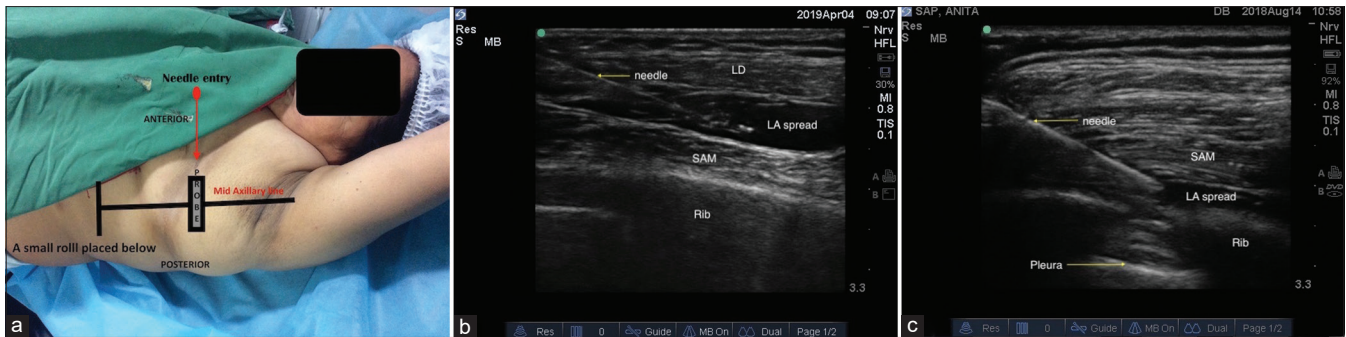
Conduct of block. (a) Placement of ultrasound probe and needle direction, (b) Superficial SAP block, (c) Deep SAP block. (SAM – serratus anterior muscle, LD – latissimus dorsi, LA – local anaesthetic)
